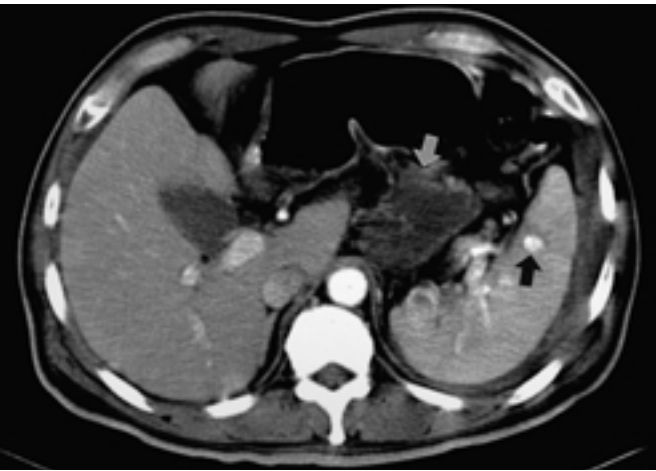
A, B. CT images from a 45-year-old man after motor vehicle collision. Axial CT image shows splenic laceration (white arrow head) with multiple pseudoaneurysms (arrow). Pseudocyst in suprapancreatic area (white arrow) is also seen.
